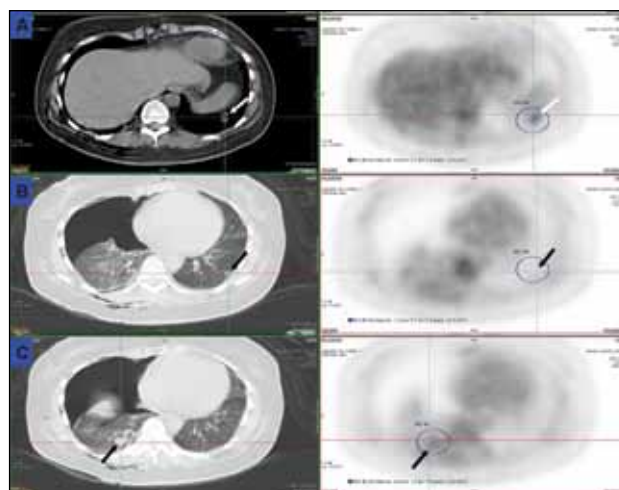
FDG increased uptake over the pulmonary nodule (1.5cm) in the left lung base (Figure 2, Panel A), bilateral adrenal gland, the nodule over subpleural left lower lung (LLL) (Figure 2, Panel B), and the nodule (1.5cm) in the right lower lung (RLL) base (Figure 2, Panel C) are reported from PET/CT whole body scan
